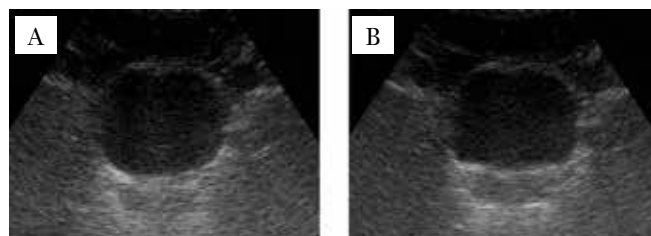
Images of the bladder and prostate using real-time transabdominal ultrasound during (A) relaxed pelvic floor muscle position and (B) contraction of pelvic floor muscles position.
